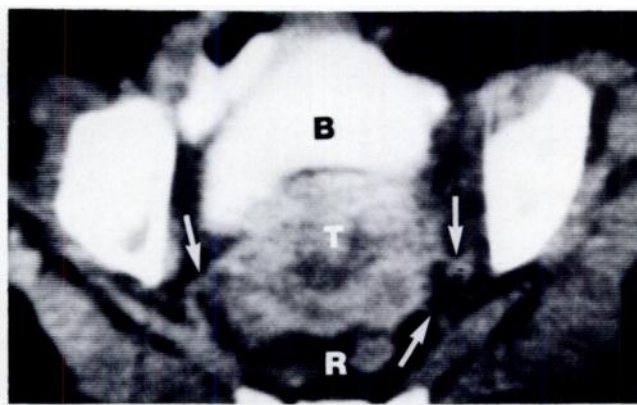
Stage IIB cervix carcinoma. CT scan through bladder (B) and rectum (R). Large cervix tumor (T) with inhomogeneous density, irregular borders, and linear soft tissue extensions to both pelvic sidewalls (arrows) confirmed at laparotomy.
